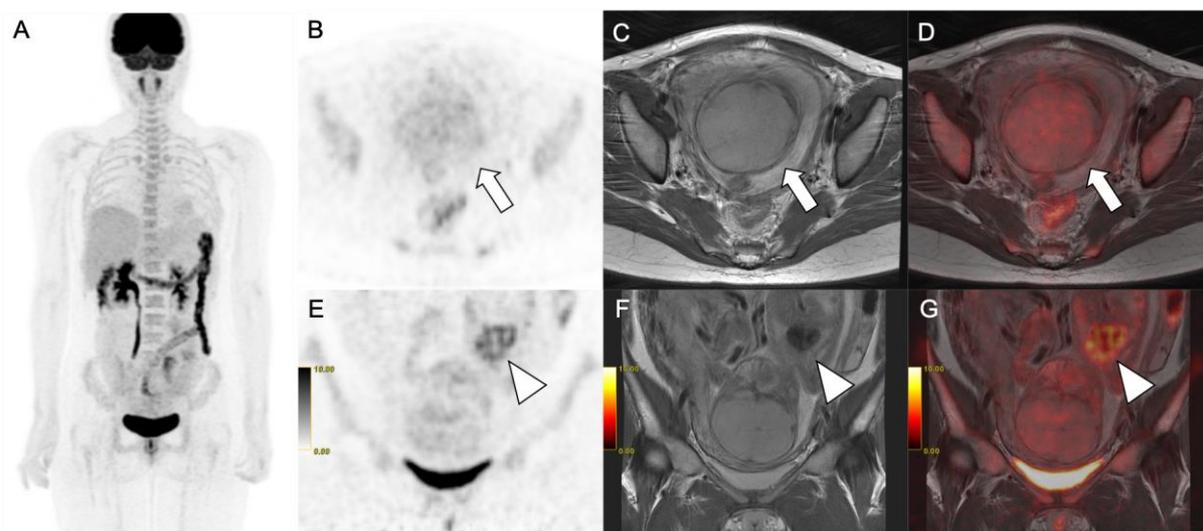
FDG-PET/MRI at 27 weeks gestation
